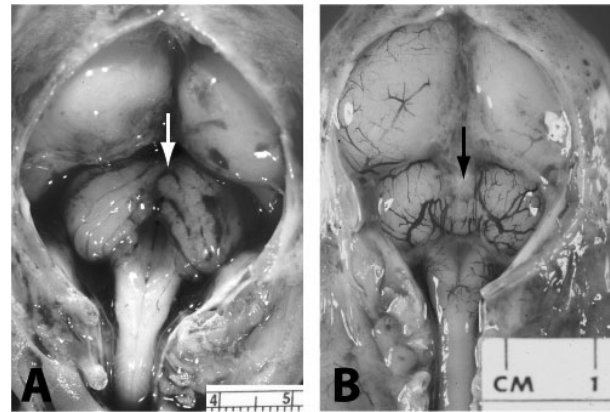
Posterior fossa *in situ*. (A) 22-week gestation fetus with JS demonstrating deficient vermis (white arrow) and large opening to the 4th ventricle. (B) For comparison: 20-week gestation fetus with intact vermis (black arrow) and small opening to the 4th ventricle. Note that the meninges have been removed in A but not B. The fetus in (B) was born spontaneously due to chorioamnionitis and probably placental abruption. Prenatal ultrasounds were normal at 13 and 18 weeks' gestation
